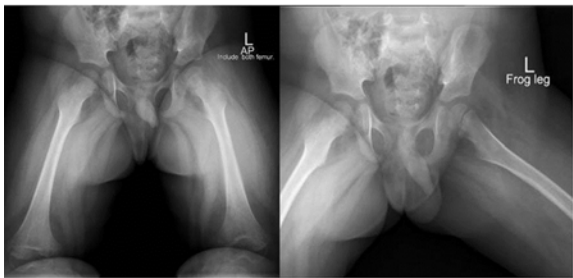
On the admission date, the radiographs of the left femur showed surrounding soft tissue swelling, osteolytic lesion and thin periosteal formation along metaphyseal-diaphyseal area. The soft tissue density around the left knee indicated intra-articular fluid.
